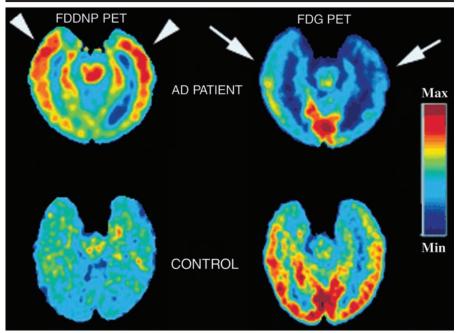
PET images comparing temporal lobe uptake of [¹⁸F]FDDNP (see text), an amyloid-binding radiotracer, and FDG, a marker of glucose metabolism, in a patient with AD (left) and a control subject (right). Note increased uptake and retention of [¹⁸F]FDDNP (arrowheads) in temporal lobes of the patient with AD, compared with those in control subject. The patient with AD still demonstrates typical findings of decreased temporal (arrows) and parietal (not shown) FDG uptake.
